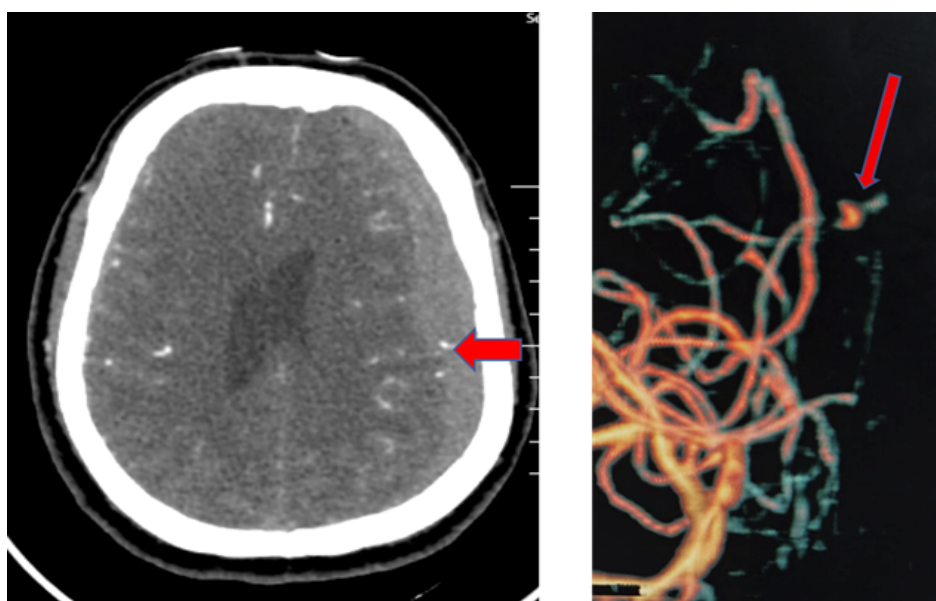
CT angiography showing saccular aneurysm arising from left M4 segment
